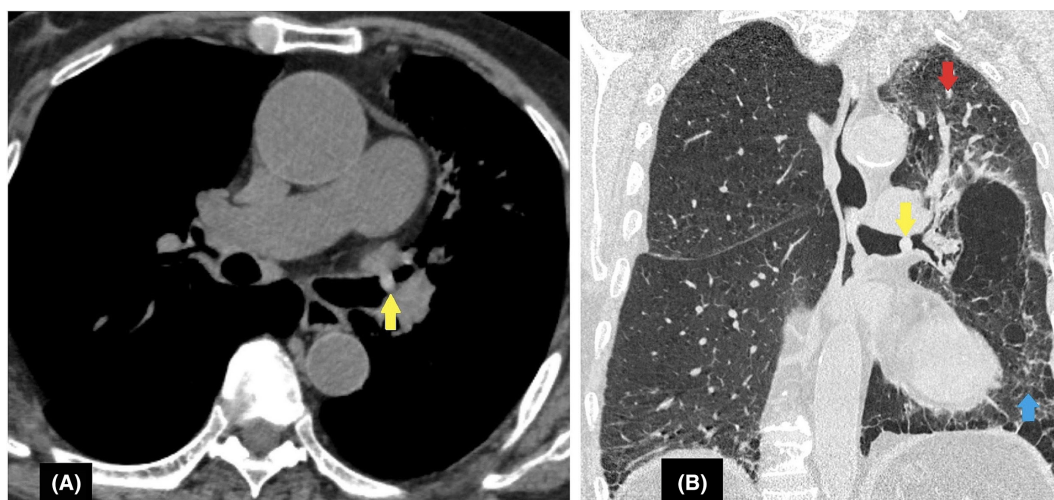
(A) An axial computed tomography (CT) section in the mediastinal window reveals an 8 × 7 mm hyperdense foreign body (FB) (yellow arrow) at the left upper lobe bronchus. (B) A coronal CT section in the lung window, shows an oval-shaped FB (yellow arrow) in the same location. Additionally, there is partial atelectasis of the left upper lobe (red arrow) and mild emphysematous changes in the left lower lobe (blue arrow).
